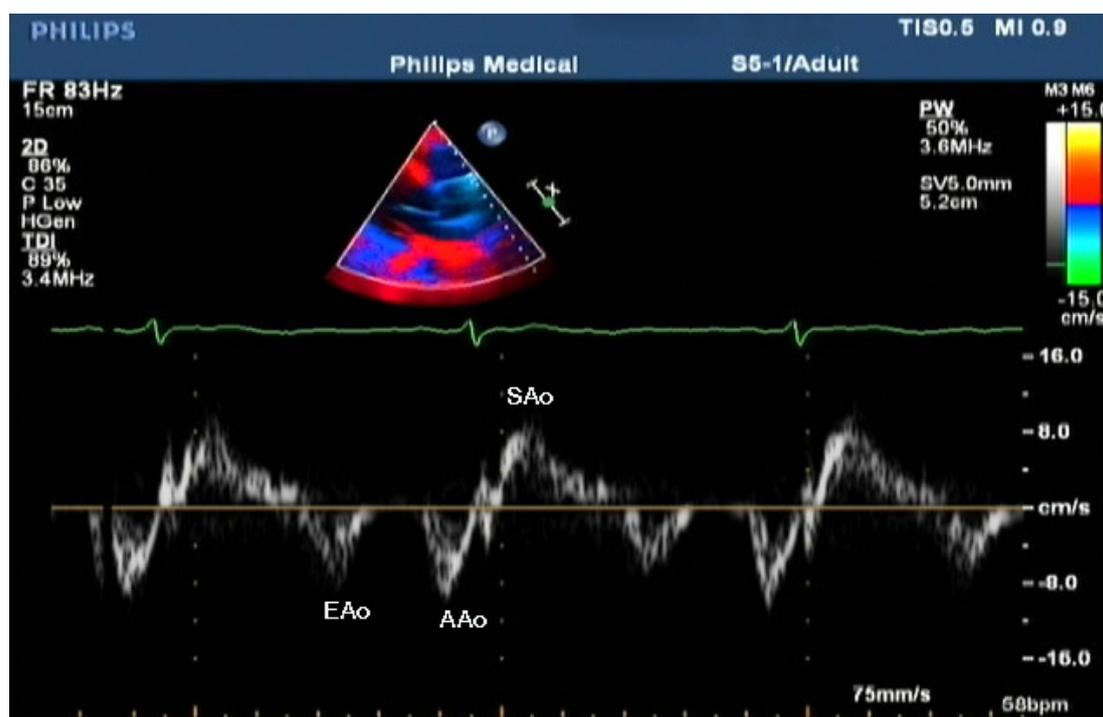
Ascending aortic upper-wall velocities were measured by TDI at a level 3 cm above the aortic cusps in long axis from the parasternal view. SAo: peak velocity during systole. EAo: early diastolic peak velocities. AAo: late contraction peak velocities.
